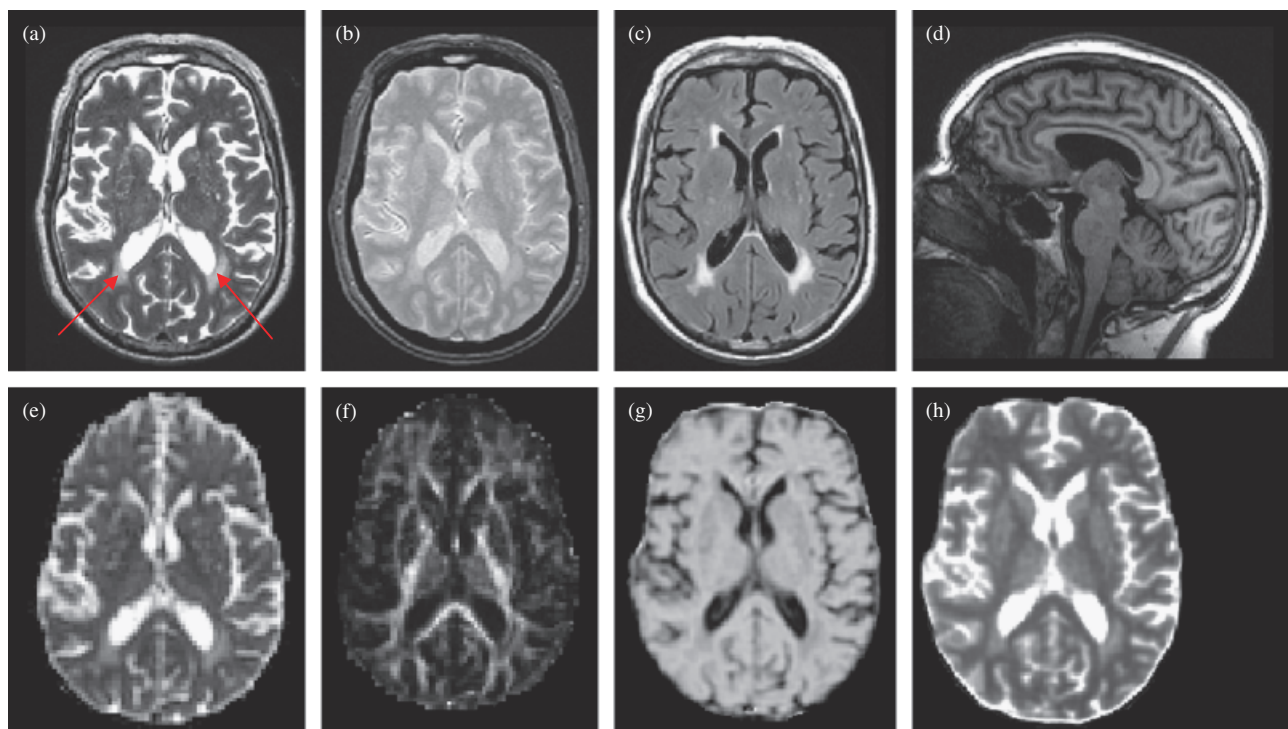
An example of the different scan data acquired in the brain MRI protocol (see Table 1); (a) T₂-weighted, (b) T₂*-weighted, (c) FLAIR-weighted, (d) high-resolution T₁-weighted volume, (e) mean diffusivity ($\langle D \rangle$), (f) fractional anisotropy (FA), (g) magnetization transfer ratio (MTR) and (h) quantitative T₁ relaxation time maps from a representative subject. All maps are obtained from the same slice location except (d). White matter lesions are indicated by the red arrows in (a). Note the increased $\langle D \rangle$ and T₁, and reduced FA and MTR of these lesions compared with surrounding normal-appearing white matter.
